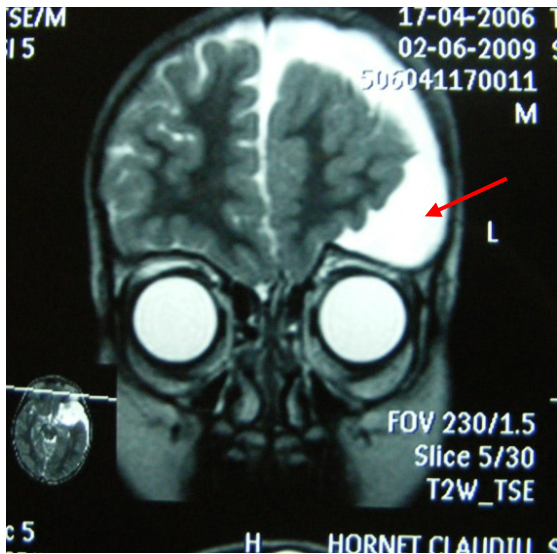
preoperative MRI aspect of a Gallasi III left cerebral hemisphere ACs
